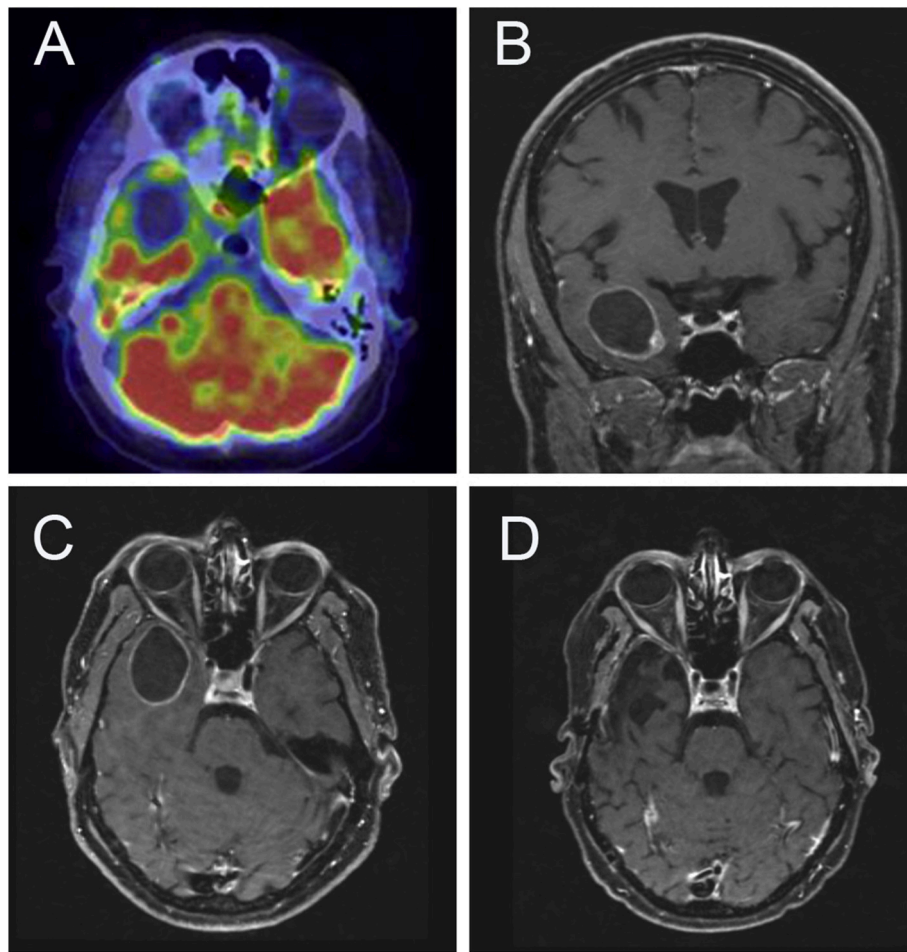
PET/CT of brain (A) revealing lack of FDG uptake corresponding to a right temporal cystic mass. MRI of brain (B, C) prior to craniotomy, showing a peripherally enhancing cystic mass in the anterior right temporal lobe, and (D) 5 years post-craniotomy, WBRT, and TIP chemotherapy, when there were post-operative changes and no recurrence of disease.
